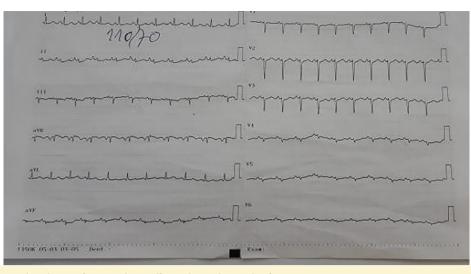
Echocardiography shows sinus tachycardia and p pulmonale signs.
